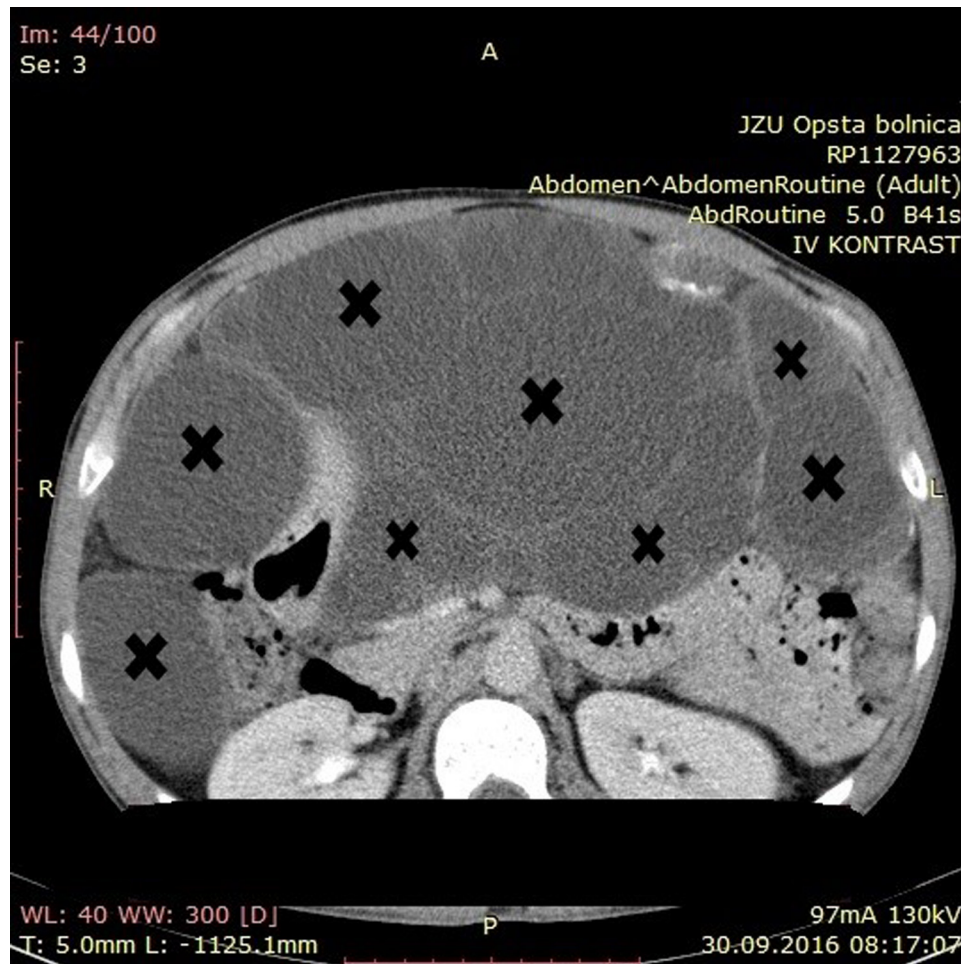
Axial CT scan of the abdomen demonstrates large multiple intra-abdominal cysts (crosses).
